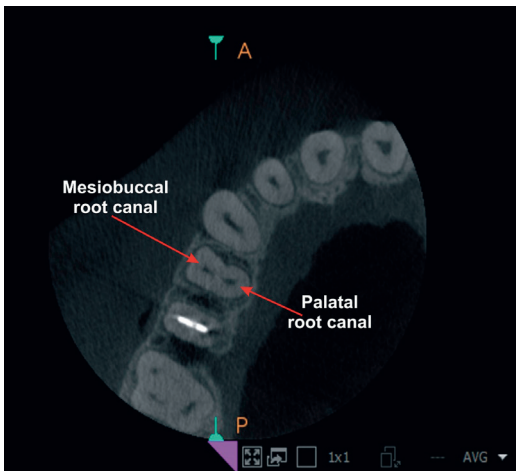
Cone beam computed tomography scanning in the horizontal plane of the coronal third of the root-tooth 14
